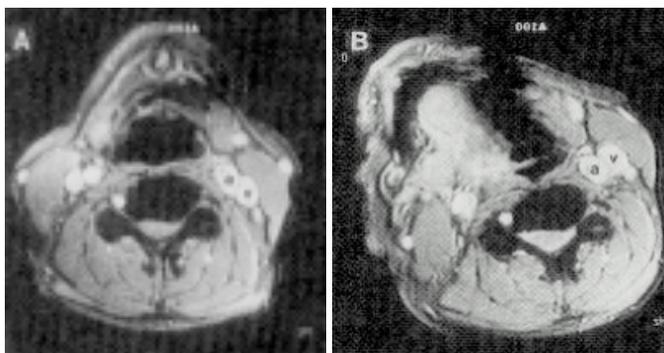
MRI of neck anatomy. In (A) the IJ vein is posterior and lateral to the CA. With rotation of the neck (B) the IJ position moves medial and superior in relation to the CA.
